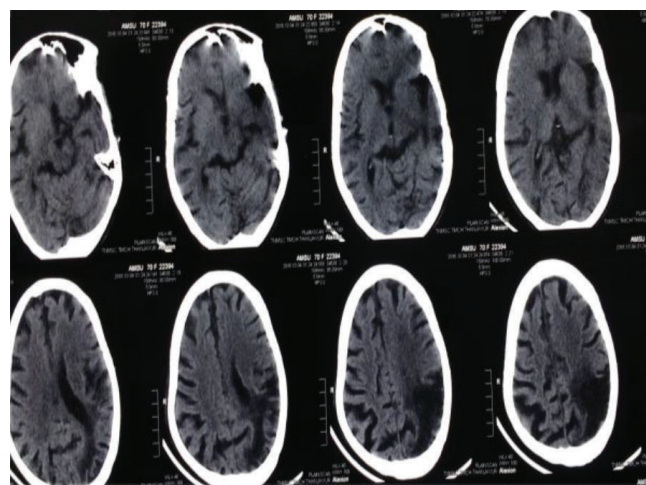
A 70 years old female presented to us with the history of 1 episode of generalised tonic clonic seizures followed by expressive aphasia. An emergency CT scan was done which showed hypodense lesion in left parieto-occipital region suggestive of chronic infarct. In addition to this gliosis was also present
